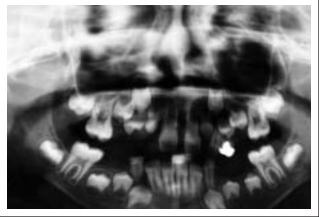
Panoramic radiograph showing all permanent teeth in iaws.
